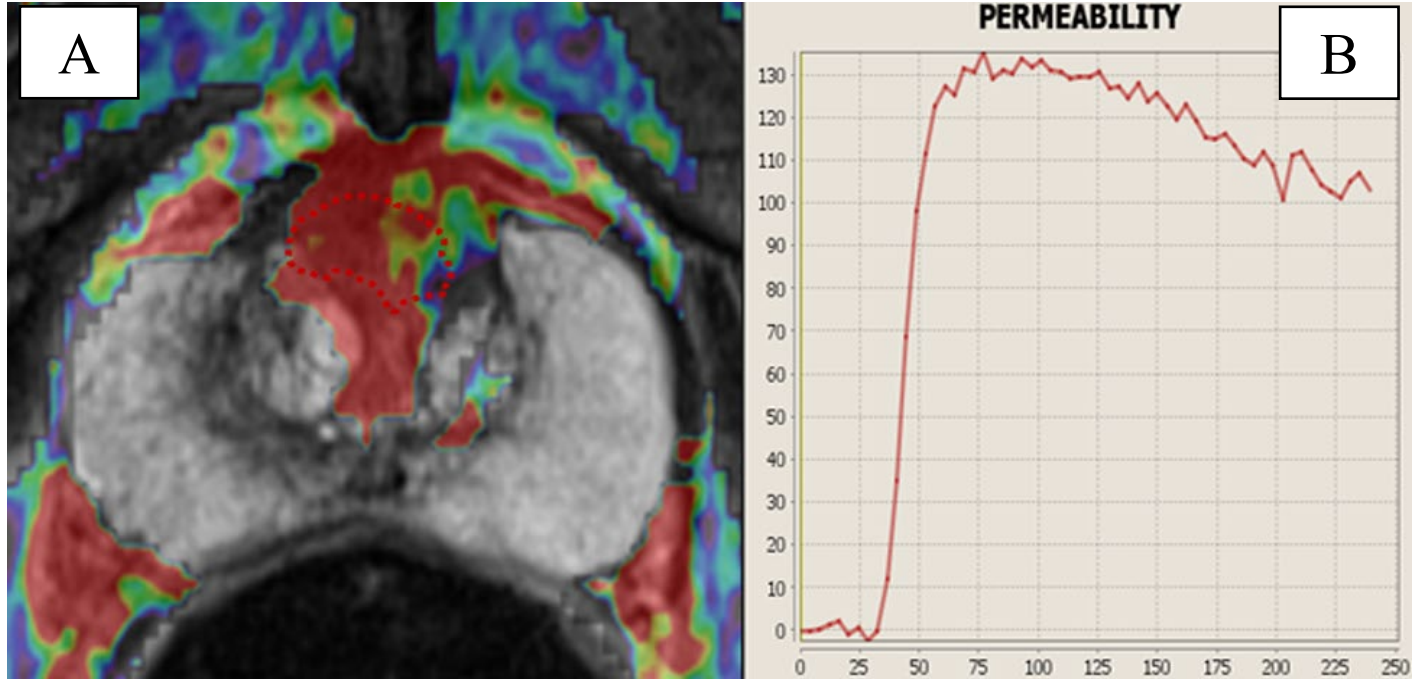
(A) DCE-MRI colour map shows early focal contrast enhancement in the TZ tumour (Red dotted circle). (B) DCE-curve which is a typical malignant curve with a high peak, rapid early enhancement (high wash-in rate) and early wash-out.
